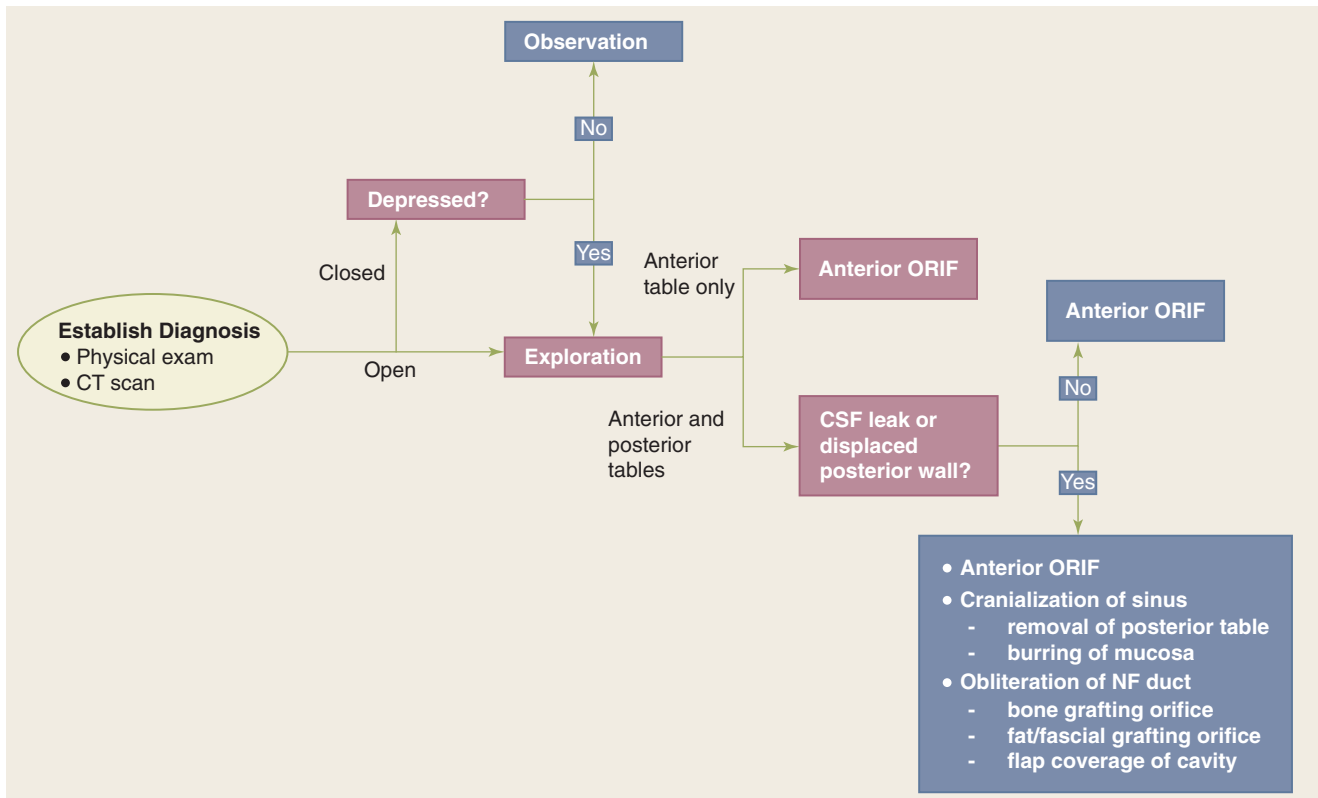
Algorithm for the treatment of frontal sinus fracture. CSF = cerebrospinal fluid; CT = computed tomography; NF = nasofrontal; ORIF = open reduction, internal fixation.
